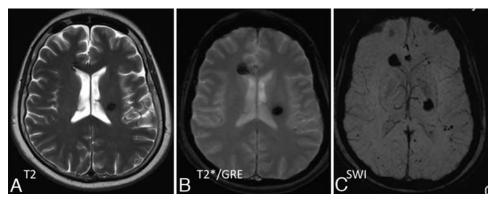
Representative T2-weighted (A), T2\*GRE (B), and SW (C) MR images obtained in a patient with a family history of familial CCM disease, who presented for routine MR imaging screening. The T2 sequences (A) revealed 2 suspected CCM lesions, which were better delineated on T2\*GRE sequences. The T2\*GRE sequences (B) also suggested perhaps 1 or 2 additional subtle lesions. The SW images (C) revealed many additional lesions throughout the brain.
